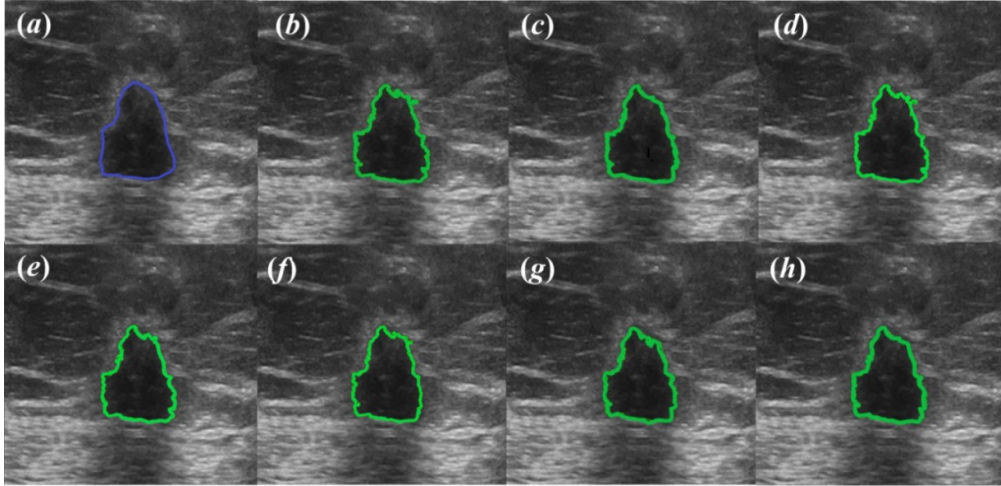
Segmentation of malignant tumor from breast ultrasound images (a) Original image indicating tumor boundary marked by the radiologist, (b) Original image indicating tumor boundary obtained after segmentation, (c) Despeckled image using Lee Sigma filter indicating tumor boundary obtained after segmentation, (d) Despeckled image using FI filter indicating tumor boundary obtained after segmentation, (e) Despeckled image using FB filter indicating tumor boundary obtained after segmentation, (f) Despeckled image using HFB filter indicating tumor boundary obtained after segmentation, (g) Despeckled image using BayesShrink filter indicating tumor boundary obtained after segmentation, (h) Despeckled image using DPAD filter indicating tumor boundary obtained after segmentation.
